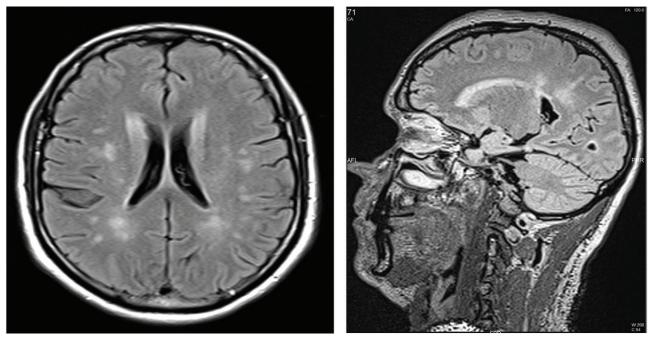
(a) Axial and (b) Sagittal T2 FLAIR images showing subcortical and periventricular hyperintense lesions
